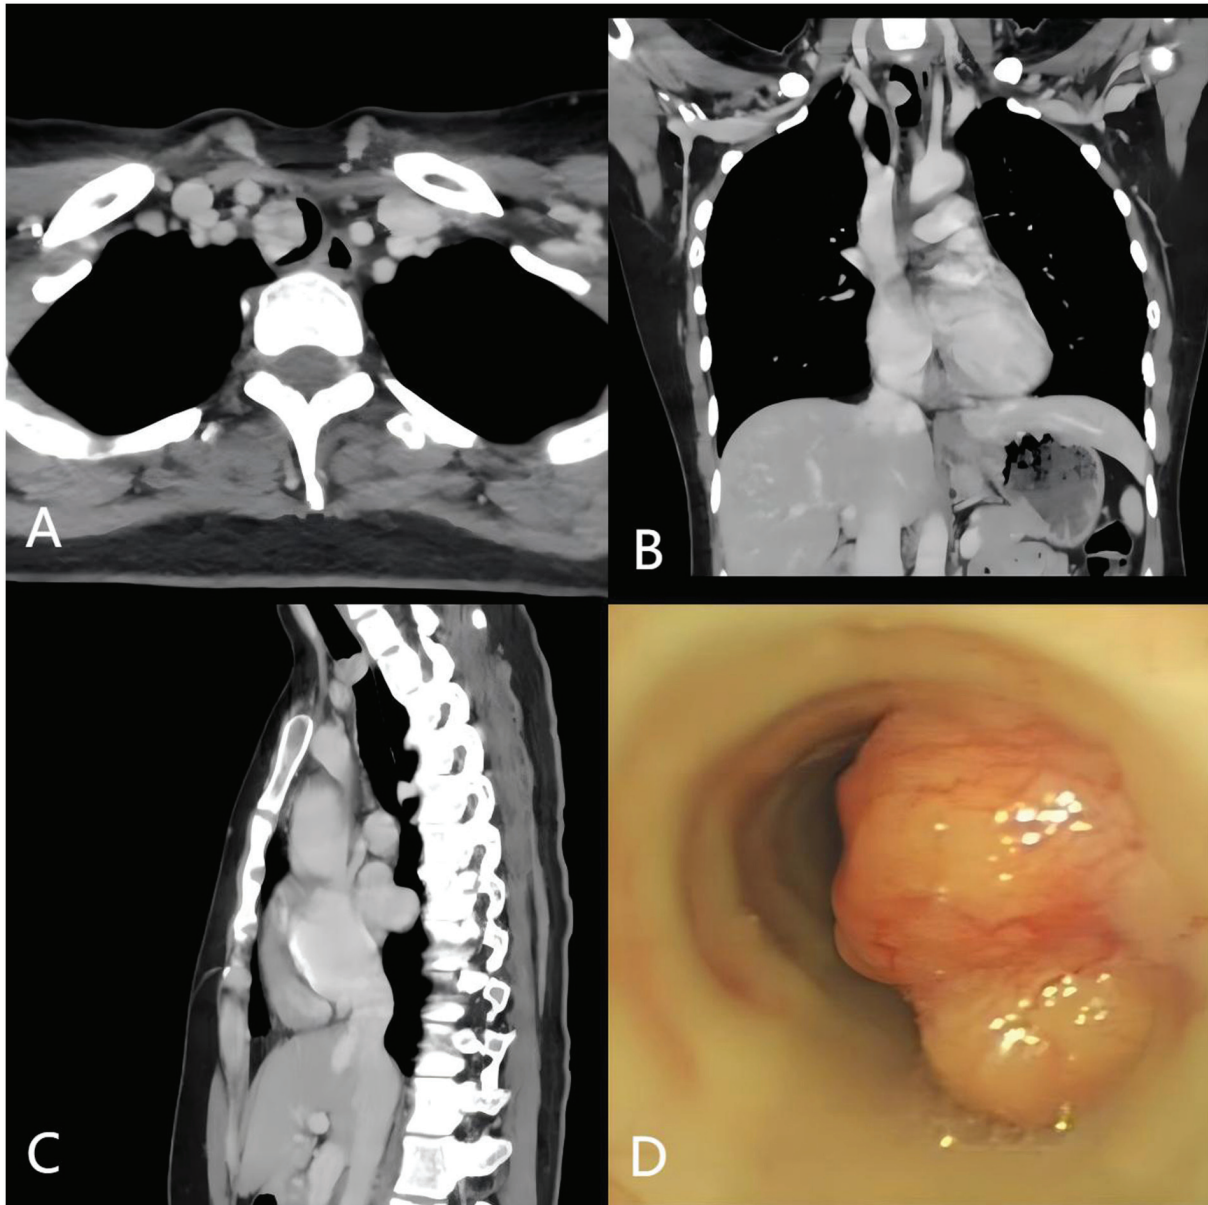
Imaging and bronchoscopic findings of the tracheal tumor. (A) Axial CT scan showing a hypervascular nodule on the posterior wall of the trachea at the level of the thoracic inlet, occupying approximately two-thirds of the tracheal lumen. (B) Coronal CT image demonstrating the vertical extent of the tracheal tumor. (C) Sagittal CT image providing a lateral view of the tumor. (D) Bronchoscopic image revealing a polypoid mass with a broad base and lobulated surface, significantly obstructing the tracheal lumen. CT, computed tomography.
